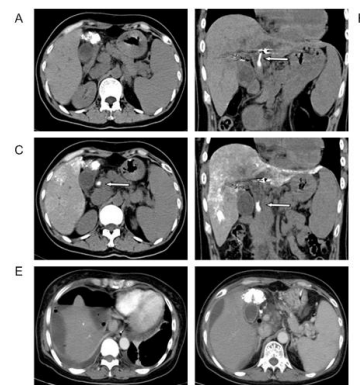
Case 2 : (A, B) Abdominal plain CT before TACE showing cancer thrombus containing lipiodol (white arrow) in the common bile duct. (C, D) Abdominal plain CT after TACE suggested that the bile duct cancer thrombus dropped to the lower end of the common bile duct (white arrow). (E, F) The abdominal enhanced CT showed free gas in the right subphrenic and gallbladder fossa (black arrow).
